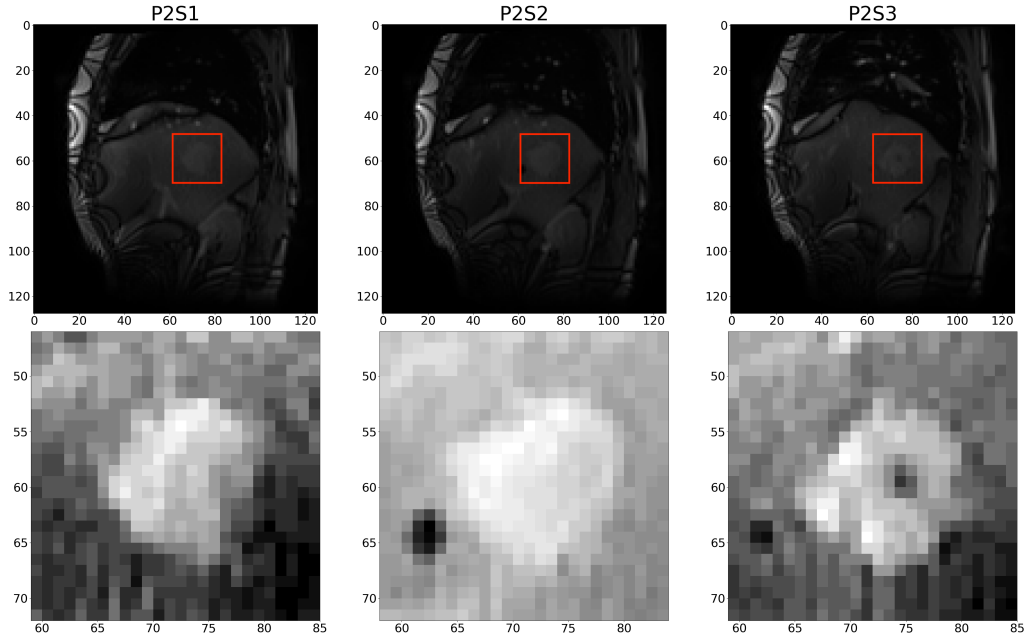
MRI images of P2 and MRI images zoomed on the tumor.
